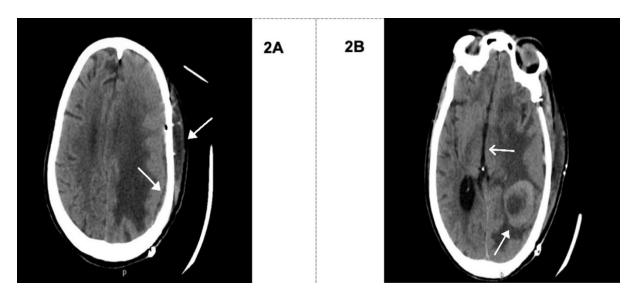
Non-enhanced CT scan of the brain. A: Post left parieto-temporal craniotomy changes; in form of left parieto-temporal subgaleal hematoma with subdural hematoma measuring 1.2 cm at maximum diameter. B: Multiple hyperdense foci at left temporal lobe at the resection site of the tumor, the largest measures are 1.3 X 1.5 X 1.5 cm in anteroposterior, transverse, and craniocaudal respectively, compatible with intraparenchymal hemorrhage, with rightward midline shift by 1 cm.
